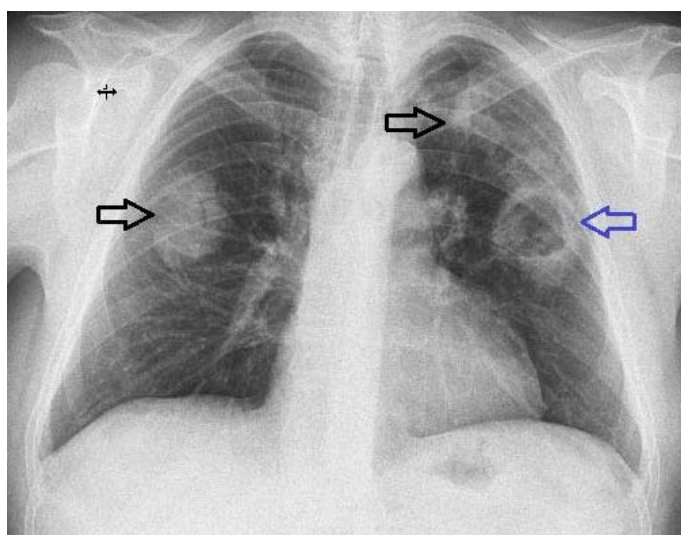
Chest X-ray PA - Multiple pseudonodular opacities, some poorly defined and relatively heterogeneous, with an apparent outline of an air bronchogram, located in both upper lung fields (black arrows), including a cavitary image with a thick contour in the middle third of the left lung field (blue arrow)
